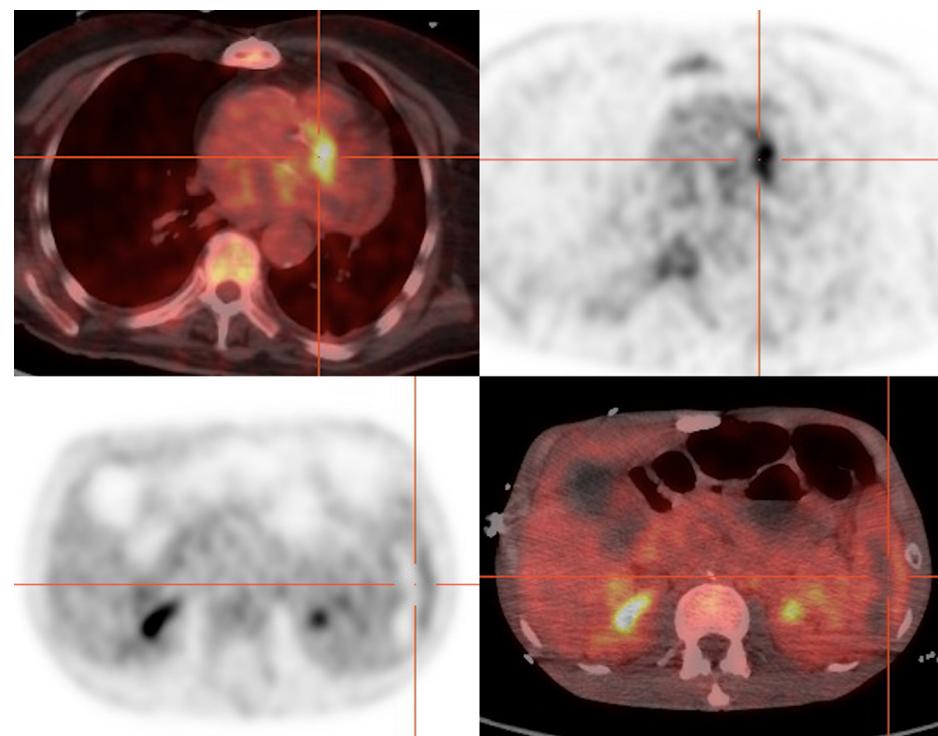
Native valvular uptake and splenic emboli on positron emission tomography/computed tomography (PET/CT) in a 75-year-old patient presenting with *Staphylococcus aureus* mitral endocarditis (12 mm vegetation on transoesophageal echocardiography). This examination is fully contributing to native valve endocarditis (NVE) diagnosis in this patient (one major criterion and one minor criterion classifying the patient as having definite NVE).
